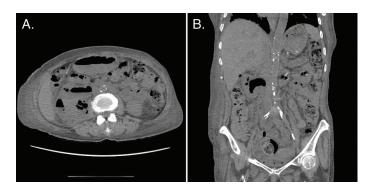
CT of right renal emphysematous pyelonephritis demonstrates gas within renal pelvis (A) and renal collecting system (B).
